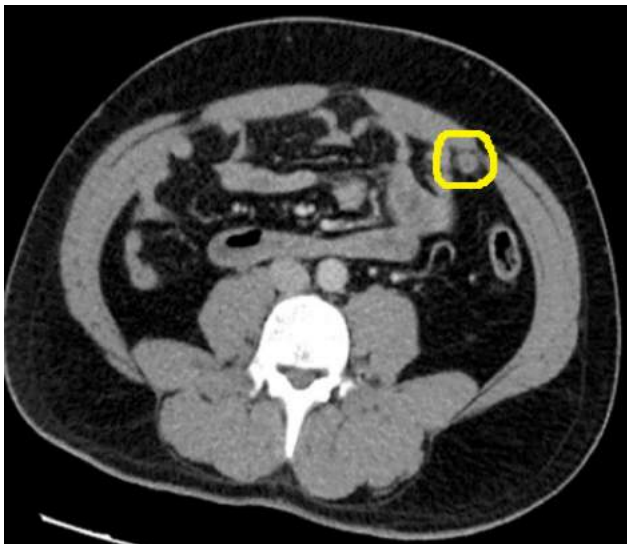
Computed tomography revealed an appendix vermiformis with a diameter of 9.7 mm in the left lower quadrant.
